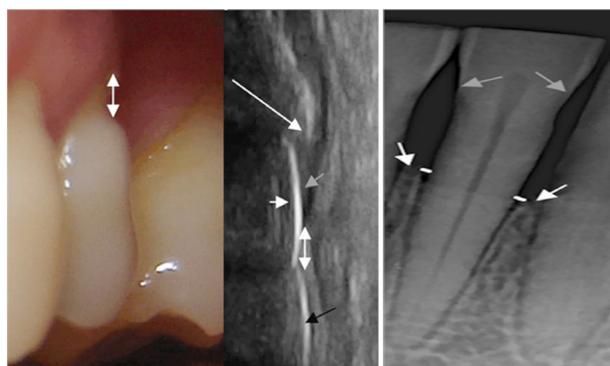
Gingival recession clinically and on ultrasound 40 MHz: tooth crown (black arrow), tooth root (short white arrow), alveolar crest (long white arrow), gingival tissue (gray arrow), gingival recession (white double arrow).
